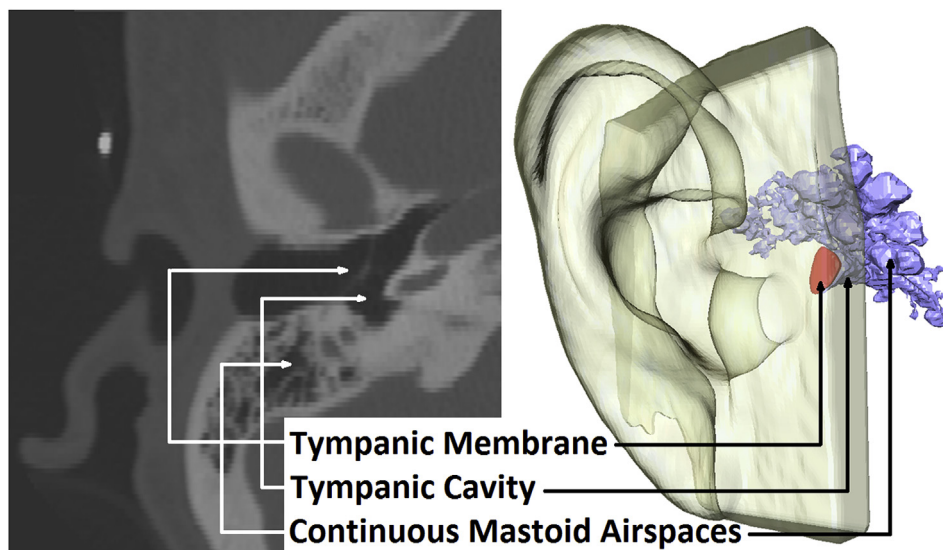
Middle ear volume was determined using a standardized three-dimensional volume reconstruction approach that involved locating the tympanic membrane on temporal bone CT scans.
